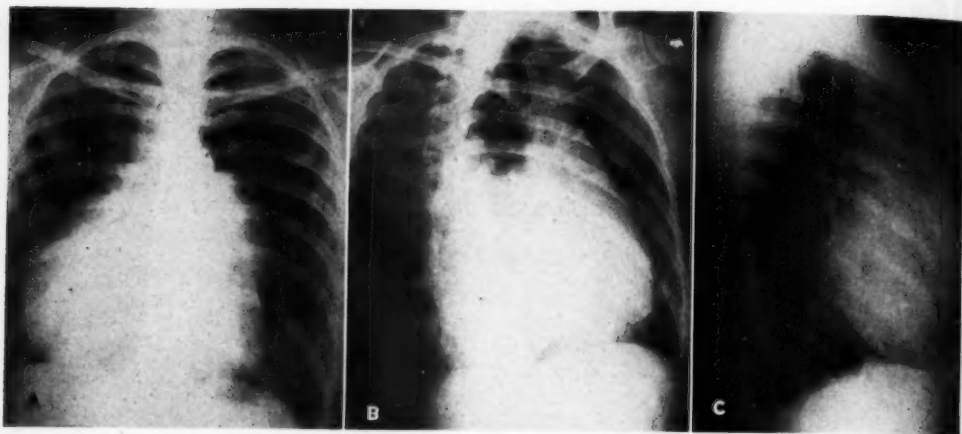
Roentgenograms of chest taken on March 13, 1944. A. Postero-anterior. B. Left anterior oblique. C. Right lateral.
